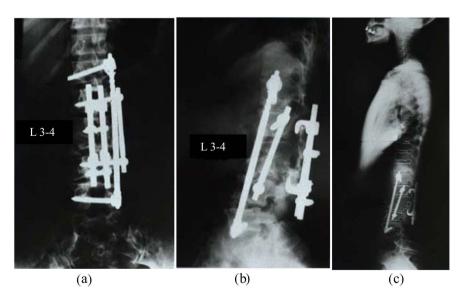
Plain X-ray radiographs at six months after surgery. (a) Anteroposterior view. (b) Lateral view. (c) Full-length lateral standing view. Lumbar lordosis was restored to 28°.
